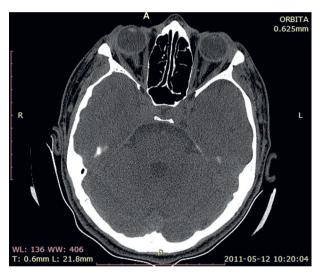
Thickening of the right posterior scleral wall on the computed tomography.
